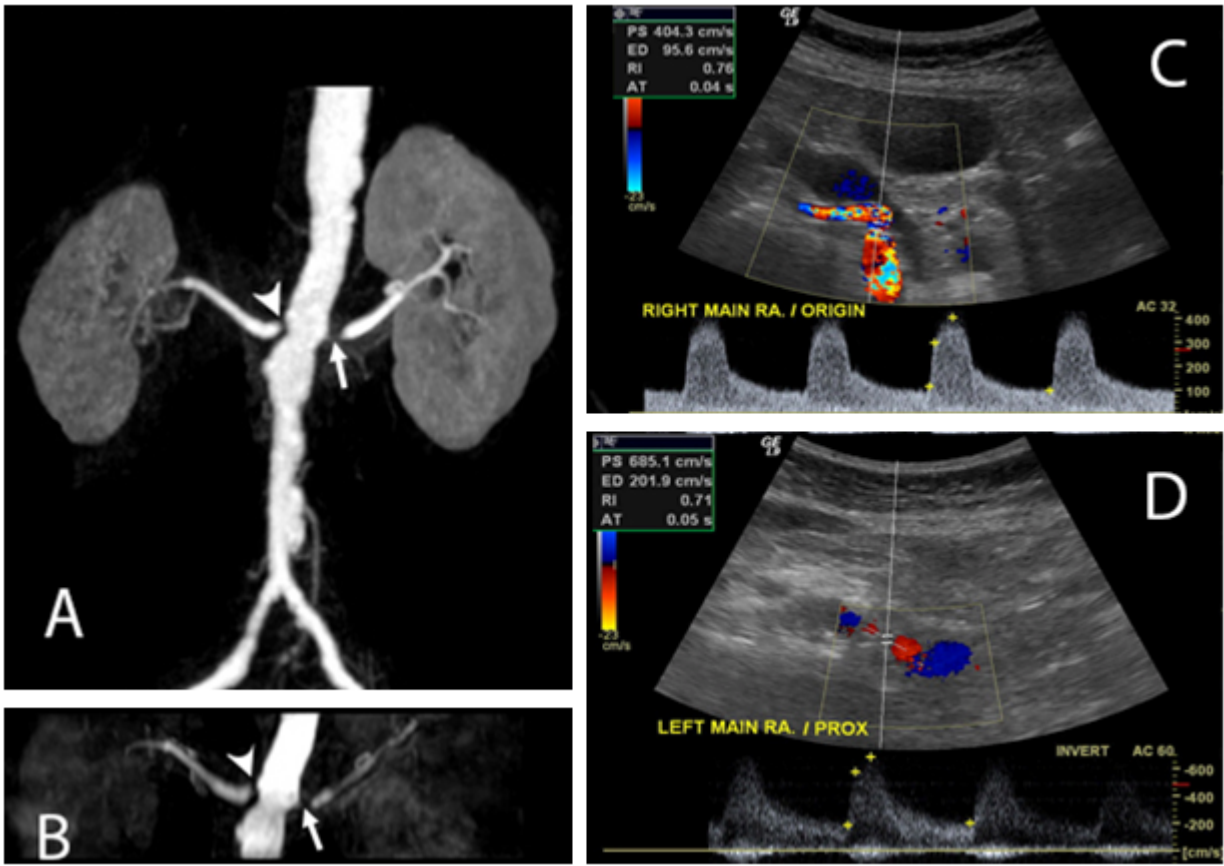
Severe bilateral renal artery stenosis was diagnosed in an 80-year-old patient. Arrow heads and arrows show severe renal artery stenosis at the proximal right and left main renal arteries in both contrast-enhanced magnetic resonance angiography (MRA) (A) and noncontrast enhanced MRA (B). Color Doppler ultrasound of right and left main renal arteries (C and D) showed aliasing color and high peak systolic velocities, indicating severe renal artery stenosis.
